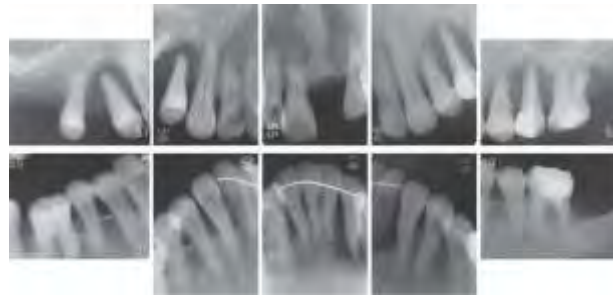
Dental radiographs during supportive periodontal therapy: Obvious crestal lamina dura was noted at the interproximal sites in the alveolar bone. No incipient bone loss was observed.
